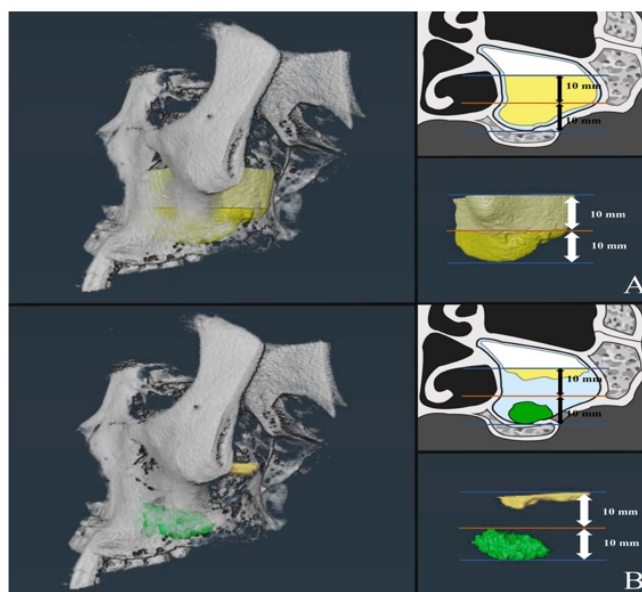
CT Scan Images Showing Preoperative and Postoperative Sinus Ventilation
